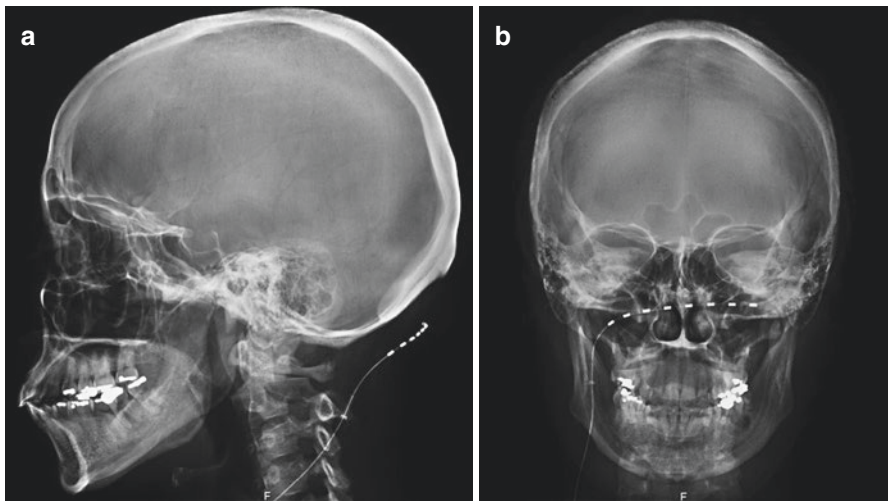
Postoperative lateral (a) and anterior-posterior (b) skull x-rays demonstrate appropriate occipital nerve stimulator electrode placement
